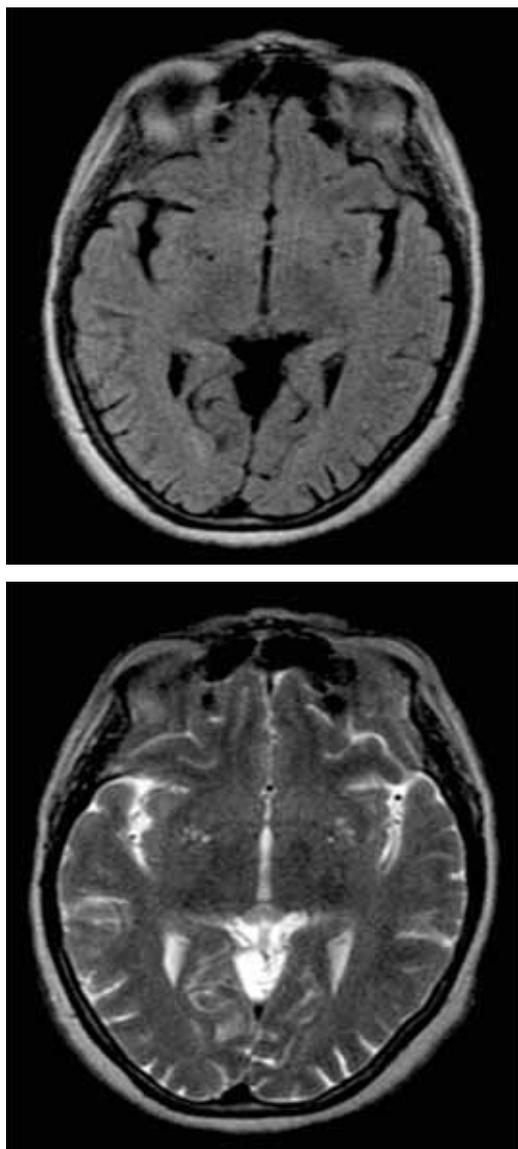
Brain MRI-normal
